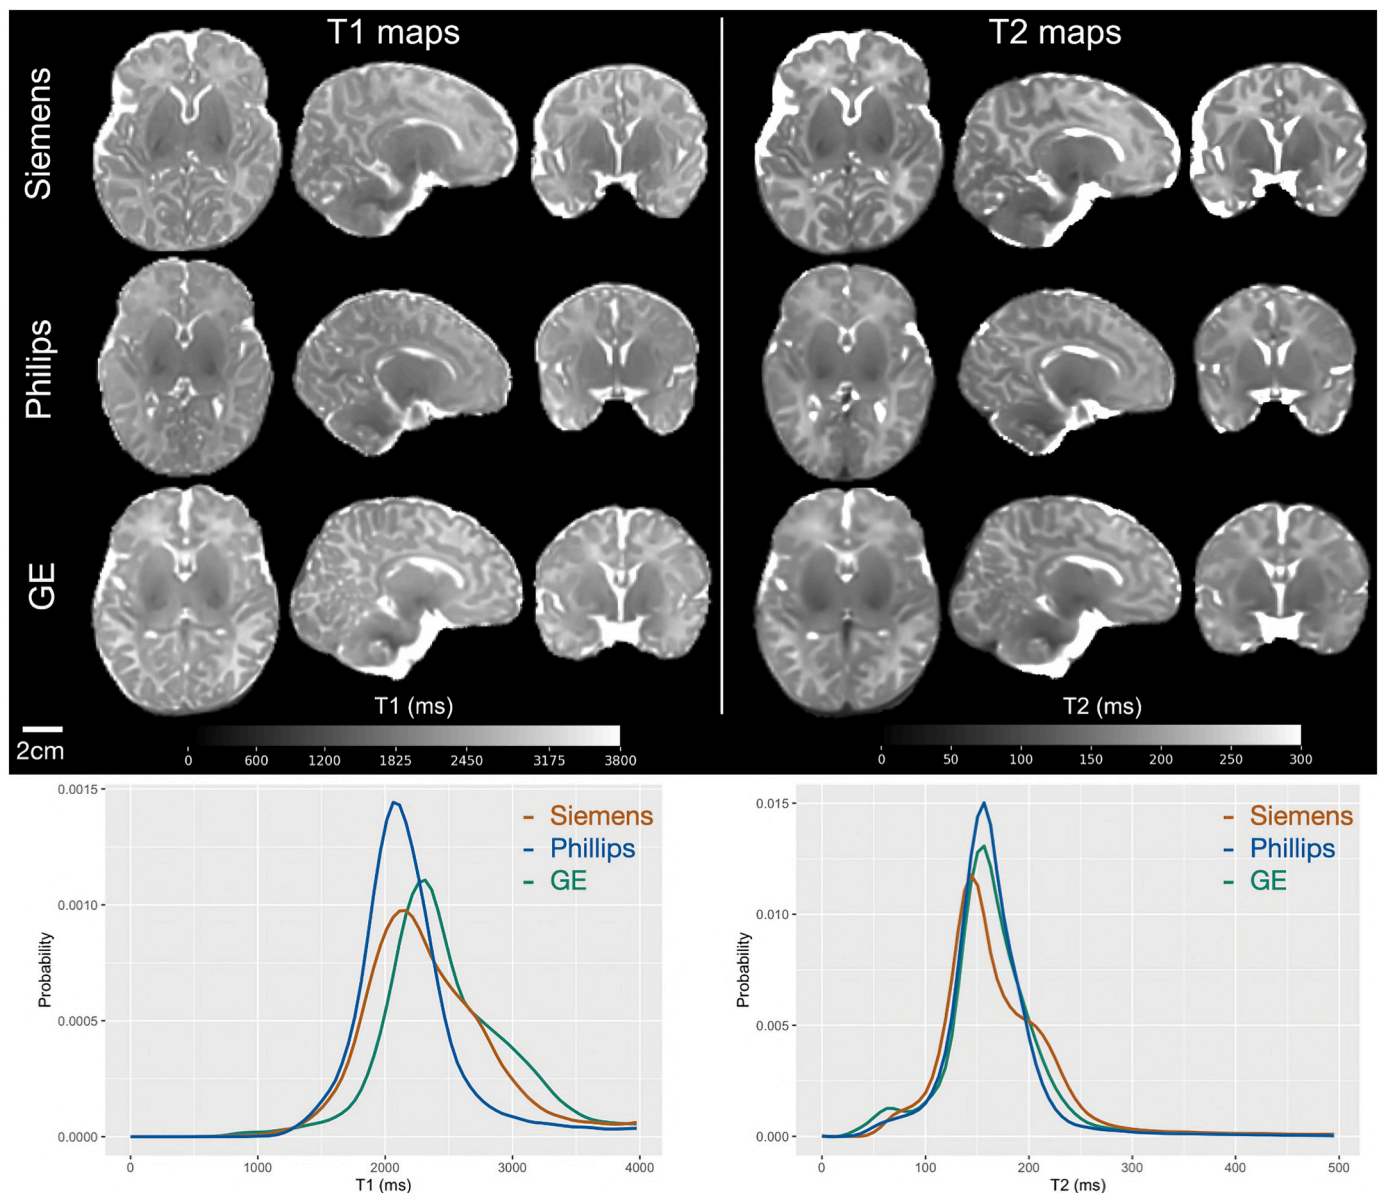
Representative axial, sagittal, and coronal slices of quantitative T1 and T2 maps acquired in age-matched (3–4 weeks) infants across the three major MRI vendors. Histograms of quantitative T1 and T2 relaxation times of these infants highlight good inter-vendor agreement.
